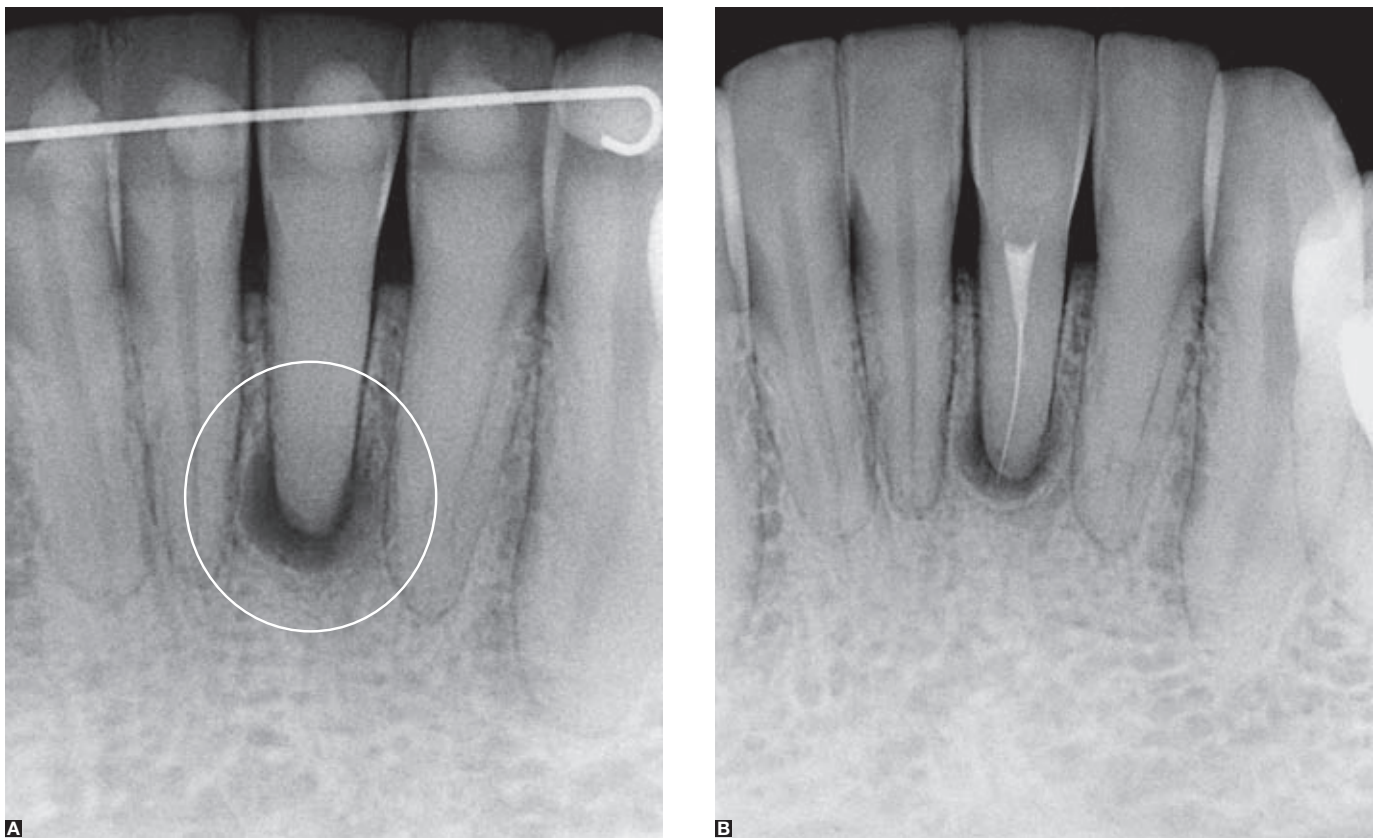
Calcific metamorphosis of the pulp obliterated the chamber and the root canal and prevented necessary endodontic treatment due to chronic periapical lesion (circle). Attempts to approach it through the canal to avoid endodontic surgery are risky because of the high probability of accidents, such as instrument fractures inside the root canal (B). However, even with a fractured instrument (B) and patient's refusal to undergo surgery, there was a reduction in lesion size.
